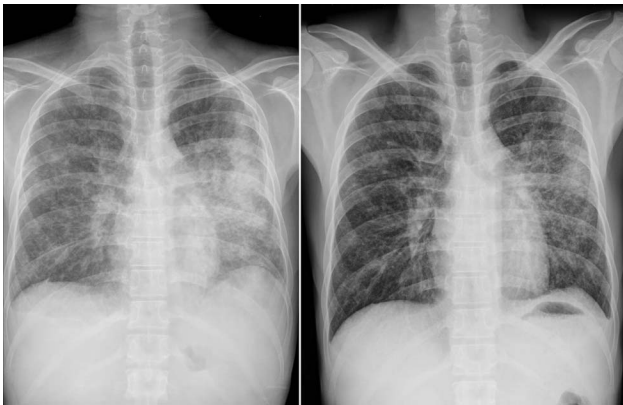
Left: Chest radiograph taken at admission showing diffuse nodular opacities in both lungs (more prominent on the left side). Right: Chest radiograph taken 2 weeks later showing resolution of the ground-glass opacities in both lungs.
